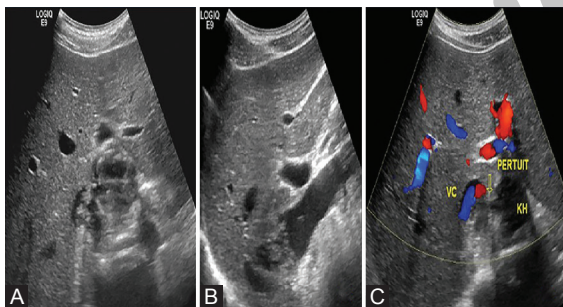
Axial (A) and sagittal (B) sonograms focusing on the liver shows hydatid cyst in the segment I ruptured into the vena cava and the hydatid materials in the light of the vena cava. The Doppler (C) shows the sluice of communication between the cyst and the vena cava and the circulating light is left of the vena cava.
